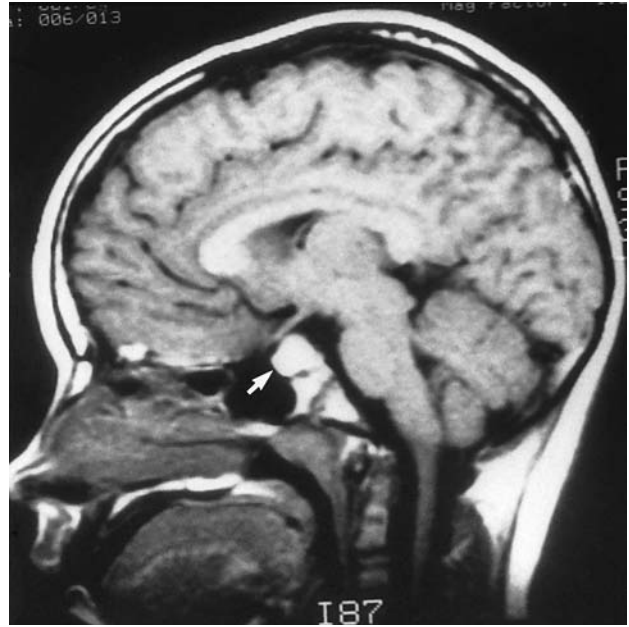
Midsagittal MRI showing an intrasellar craniopharyngioma (*arrow*). A transsphenoidal approach is suitable for tumor resection.
